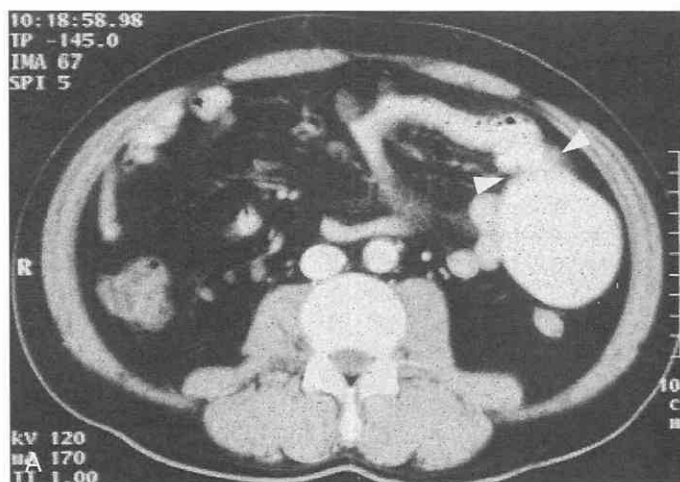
Primary jejunal carcinoma. *A*, CT scan shows bowel obstruction (*arrowheads*) at the site of the tumor. *B*, On small-bowel follow-through, a polypoid mass (*arrows*) and luminal narrowing are seen in the jejunum along with proximal bowel loop dilatation.
